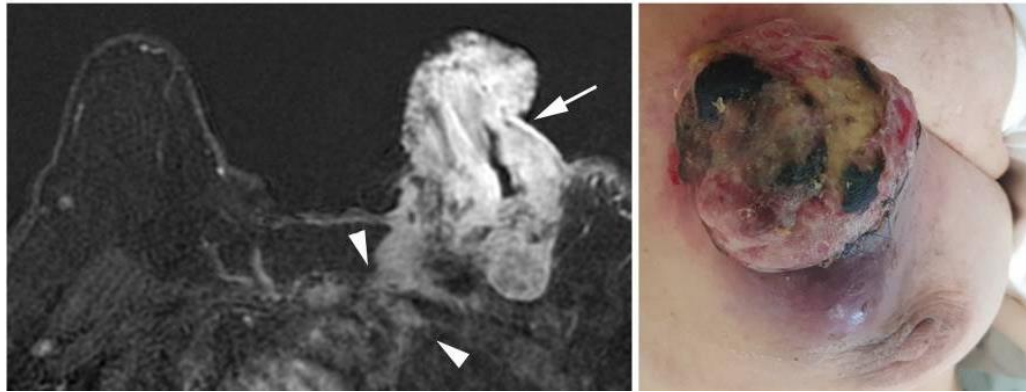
MRI image of rib extension and skin ulceration in the left breast (Koh & Kim, 2019).
